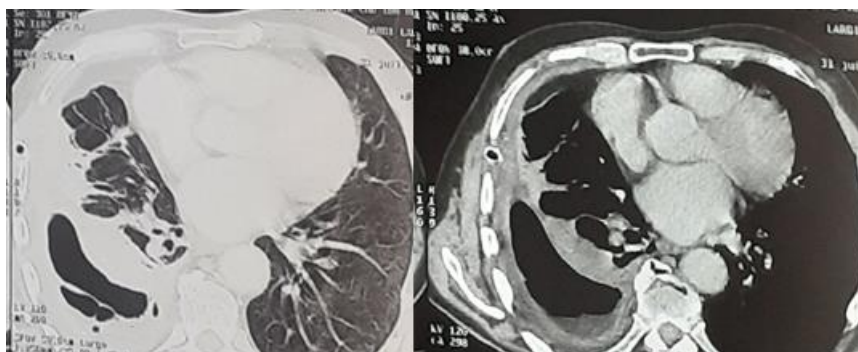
Chest CT scan after unsuccessful medical thoracic drainage showing an encysted pyopneumothorax.
